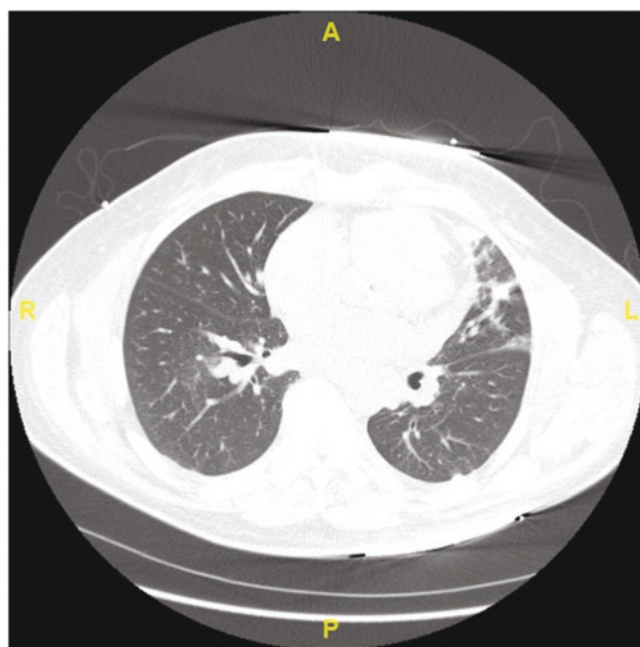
Chest CT showing mediastinal lymphadenopathy, left upper lobe consolidation, and perilymphatic nodules in the right upper and lower lobes
